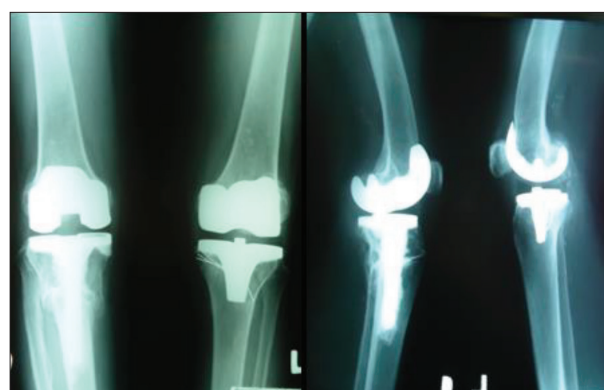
X-rays of both knees in a patient with a proximal metaphysis stress fracture of the right tibia, associated with severe bilateral knee osteoarthritis, treated with bilateral total knee arthroplasty in two acts, nine months after the first modular total knee arthroplasty
